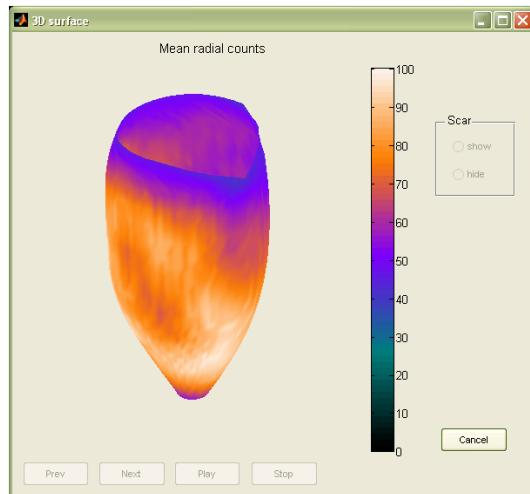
Graphical user interface of the 3 dimensional visualization for SPECT images.
